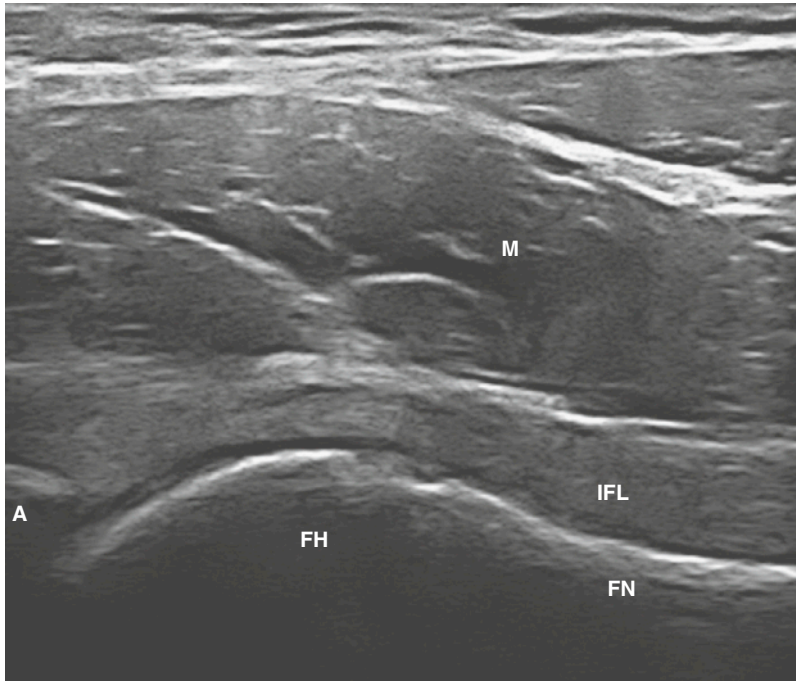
ILIOFEMORAL LIGAMENT. Ultrasound shows the iliofemoral ligament (IFL). A, acetabulum; FH, femoral head; FN, femoral neck; M, iliopsoas muscle.
